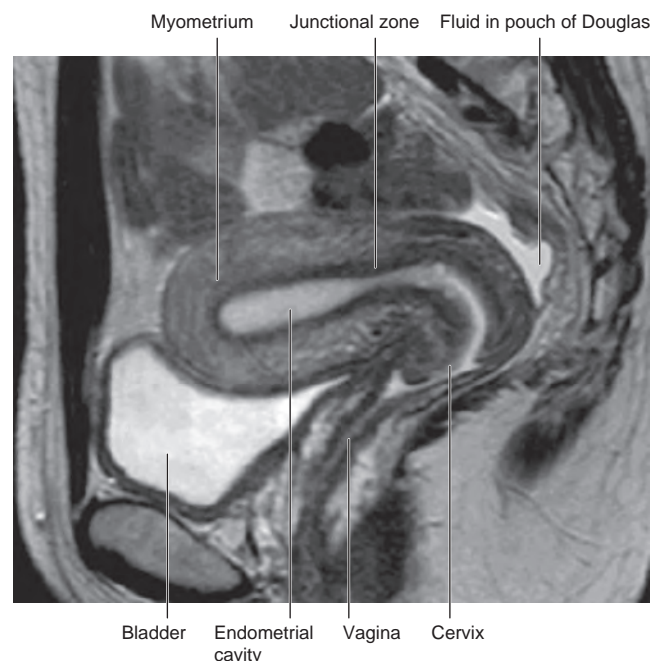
Normal anatomy of the pelvic structures on T2-weighted magnetic resonance image showing the zonal anatomy of the uterus. (From Standing S. Gray's anatomy: the anatomical basis of clinical practice. 40th ed. London: Churchill Livingstone; 2008.)
